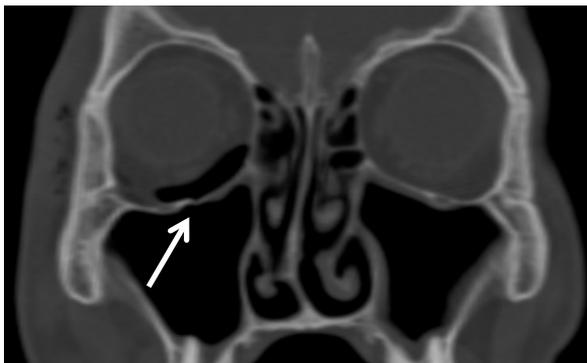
Blow-out fracture with herniation of soft tissue, right eye (23-year-old male). CT, coronal section: fracture of the orbital floor (white arrow), the eye socket is filled with air from the maxillary sinus. Due to the loss of the abutment, the eye sinks in the orbital cavity (enophthalmus).
